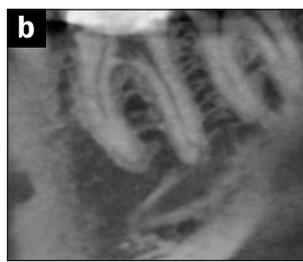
CBCT allows for a 3-D evaluation of resorptive defects. This sagittal slice aided in assessing the resorptive defect's furcal extent.
